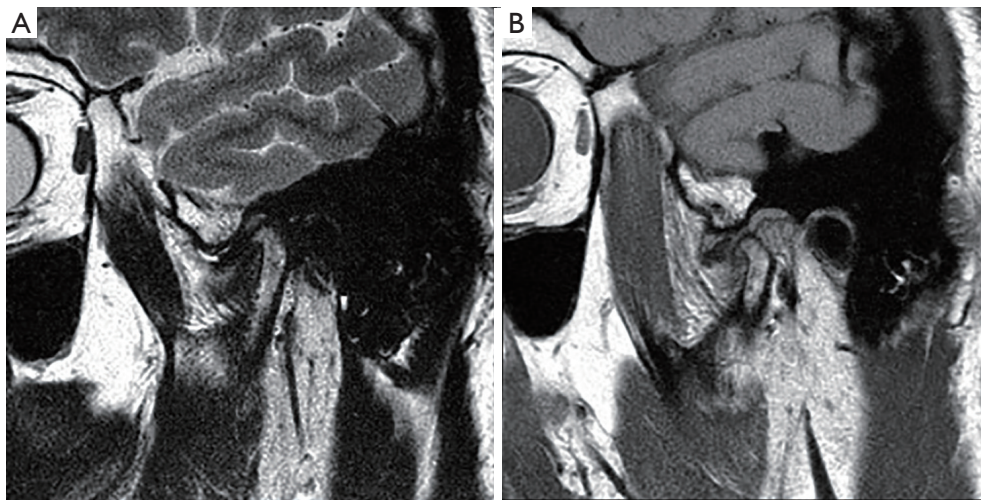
(A) MRI of the temporomandibular joint in the closed mouth view shows anterior disc displacement and a moderate amount of condylar flattening and osteophyte formation. (B) Open mouth view shows anterior disc displacement without reduction.
